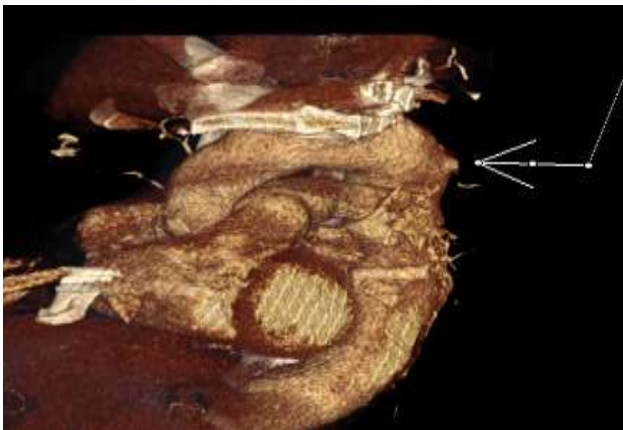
Three-dimensional CT reconstruction showing the anatomical location and morphology of the penetrating ulcer in the descending thoracic aorta, distal to the left subclavian artery
